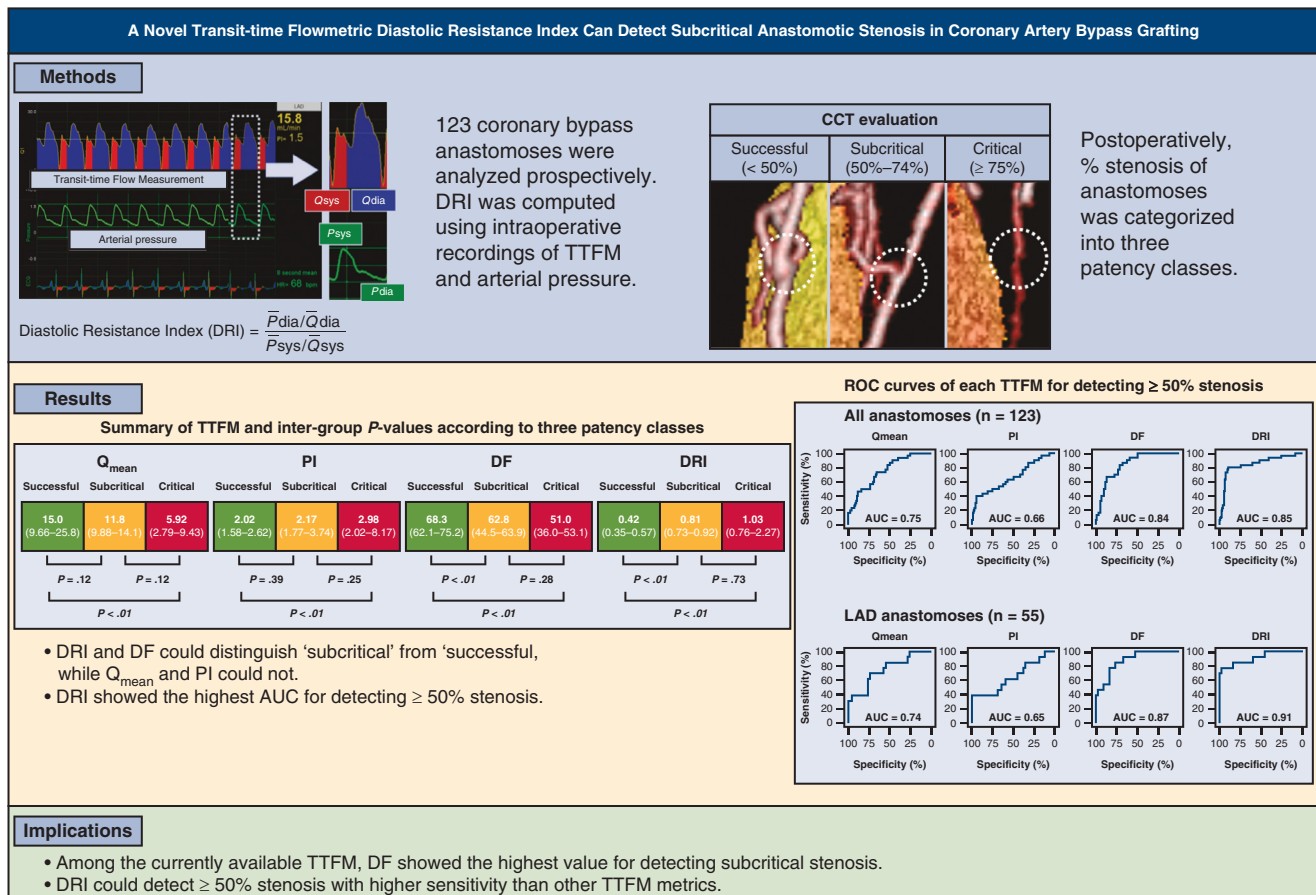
Graphical summary of the study showing that the new transit-time flow metric (TTFM) parameter diastolic resistance index (DRI) shows high diagnostic ability for detecting subcritical anastomotic stenosis in coronary artery bypass grafting. *CCT*, Coronary computed tomography; *sys*, systole; *dia*, diastole; *ROC*, receiver-operating characteristic; *Q_{mean}*, mean graft flow; *PI*, pulsatility index; *DF*, diastolic filling; *AUC*, area under the curve; *LAD*, left anterior descending artery.
